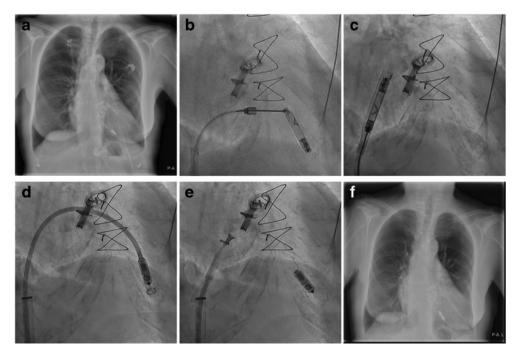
Replacement of the Nanostim for a Micra leadless pacemaker. Panel A: X-ray of a nonfunctioning in situ Nanostim leadless pacemaker. Panel B: the single-loop snare is looped around the docking button of the Nanostim. Panel C: Device extracted from the right ventricular cavity. Panel D&E: Micra TPS placement at a slightly different location in the right ventricle. Panel F: X-ray of the Micra TPS
